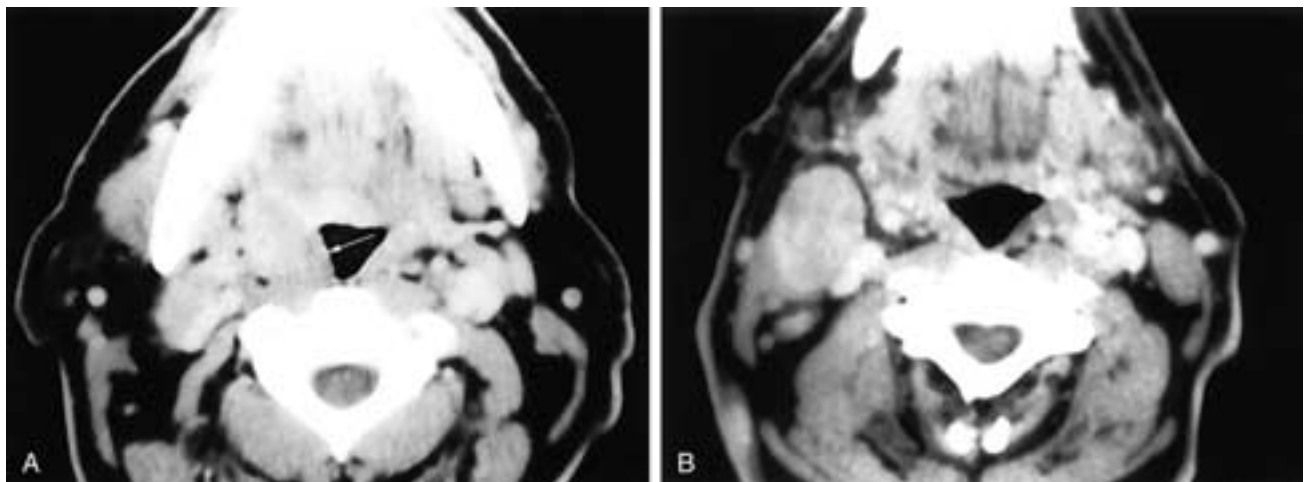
Axial CT scans from cranial (A) to caudal (B) show thickening of the right pharyngeal tonsil and oropharyngeal wall (arrow in A) and an enlarged right level II node. The lymph node is fairly homogeneous, and there is no involvement of the adjacent fat planes. This patient had large cell lymphoma.
